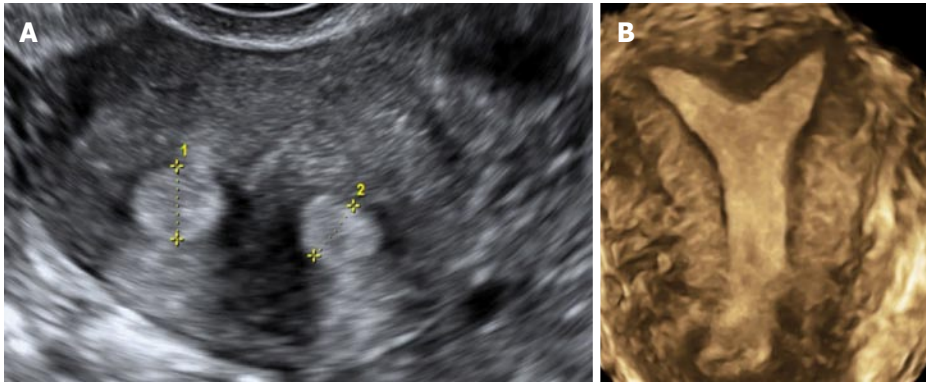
Septate uterus. A: Transverse 2D ultrasound image of a septate uterus showing the presence of 2 endometrial cavities; B: Coronal 3D ultrasound image of a partial septate uterus with the external cleft < 1 cm but internal indentation > 1.5 cm. 3D: Three-dimensional; 2D: Two-dimensional.
